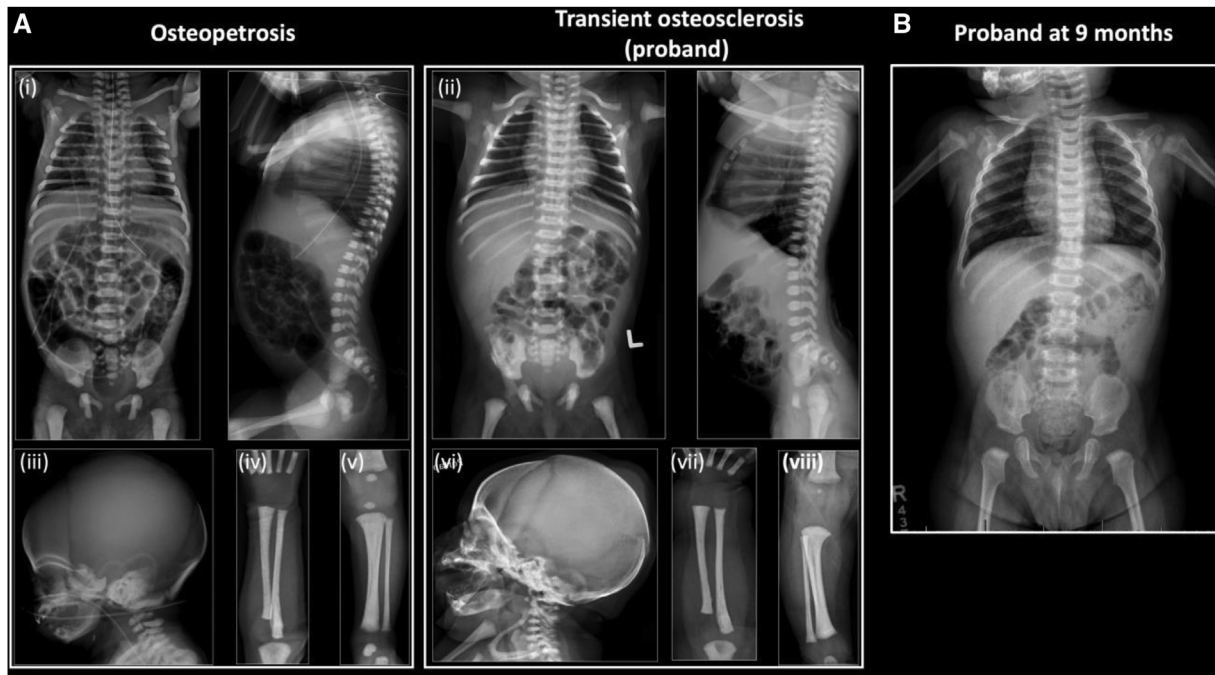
A, Comparison of radiographs from 8-day-old child with infantile osteopetrosis (*left panel*) and the proband with transient osteosclerosis at 1 day of life (*right panel*). (i) and (ii) show coronal view (*left*) and sagittal view (*right*) of chest, abdomen, and pelvis; (iii) and (vi) skull sagittal view; (iv) and (vii) left forearm; and (v) and (viii) lower limb. B, Chest, abdomen, and pelvis radiographs of proband with transient osteosclerosis at 9 months showing complete resolution of radiologic findings.
